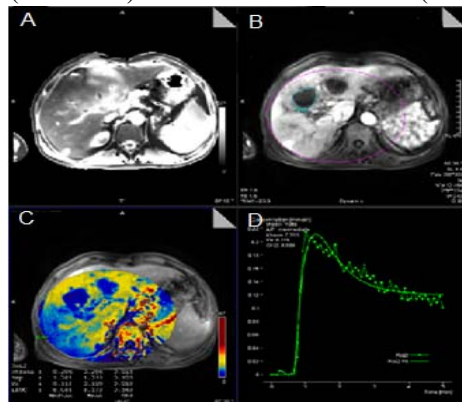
DCE-MRI: CAIPIRINHA-VIBE
